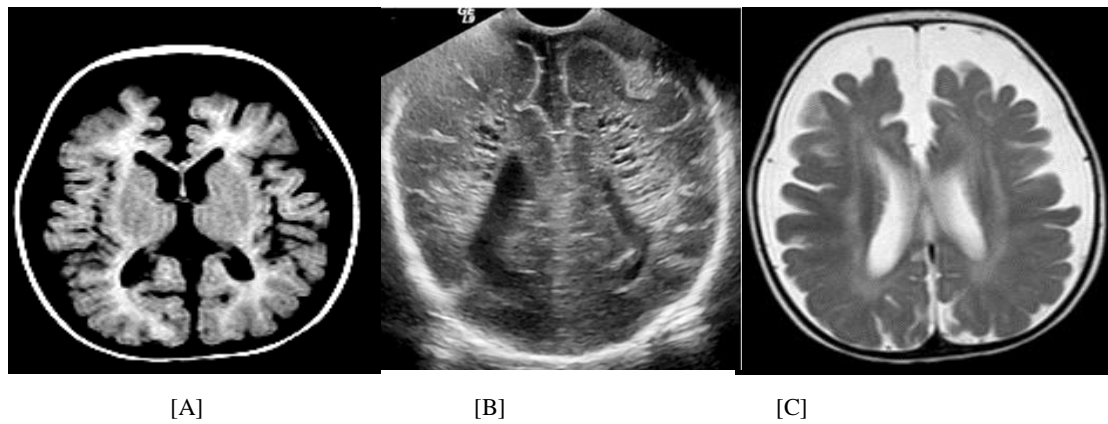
A case of periventricular hypoxic ischemic leukoencephalopathy of Female neonate 48-day old presented clinically by seizures and abnormal eye movements, with subsequent hypotonia. A Coronal Views [Anterior Fontanelle]: there is evidence of periventricular cystic changes within echogenic white matter, with mild ventricular dilatation, which is consistent with periventricular leukomalacia. B Axial T2 & FLAIR WIs: show diffuse cerebral atrophic changes with widening of ventricular system in addition to bands of hyperintense signals in periventricular white matter
